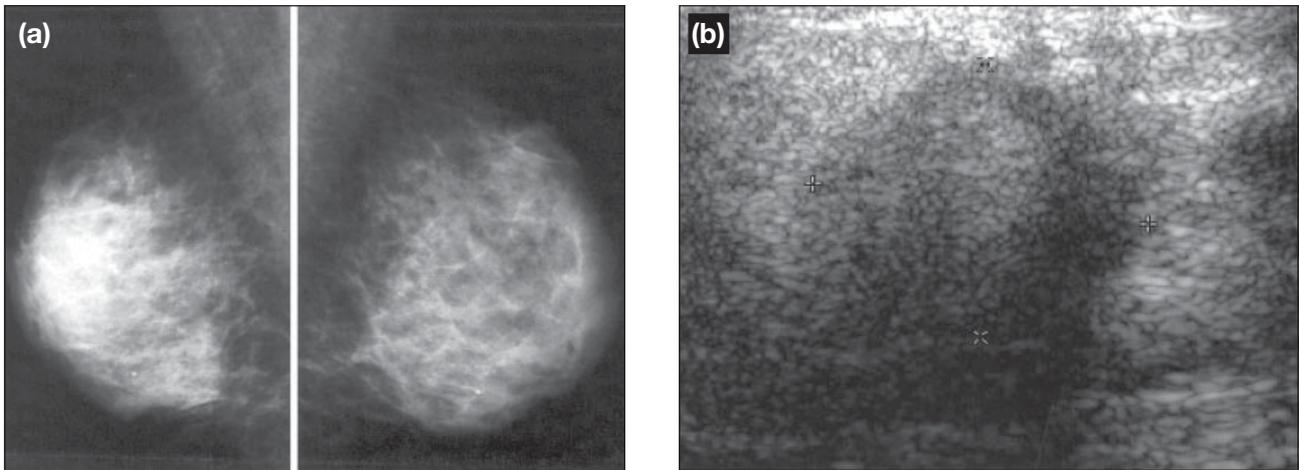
Lymphocytic mastitis (diabetic mastopathy). (a) Bilateral medio-lateral oblique views show ill-defined asymmetrical density at the retroareolar region of the right breast, which is the typical location of diabetic mastopathy. (b) Ultrasound study shows an irregular mass with posterior shadowing at the subareolar region, resembling carcinoma. Core biopsy confirmed the diagnosis of lymphocytic mastitis.
